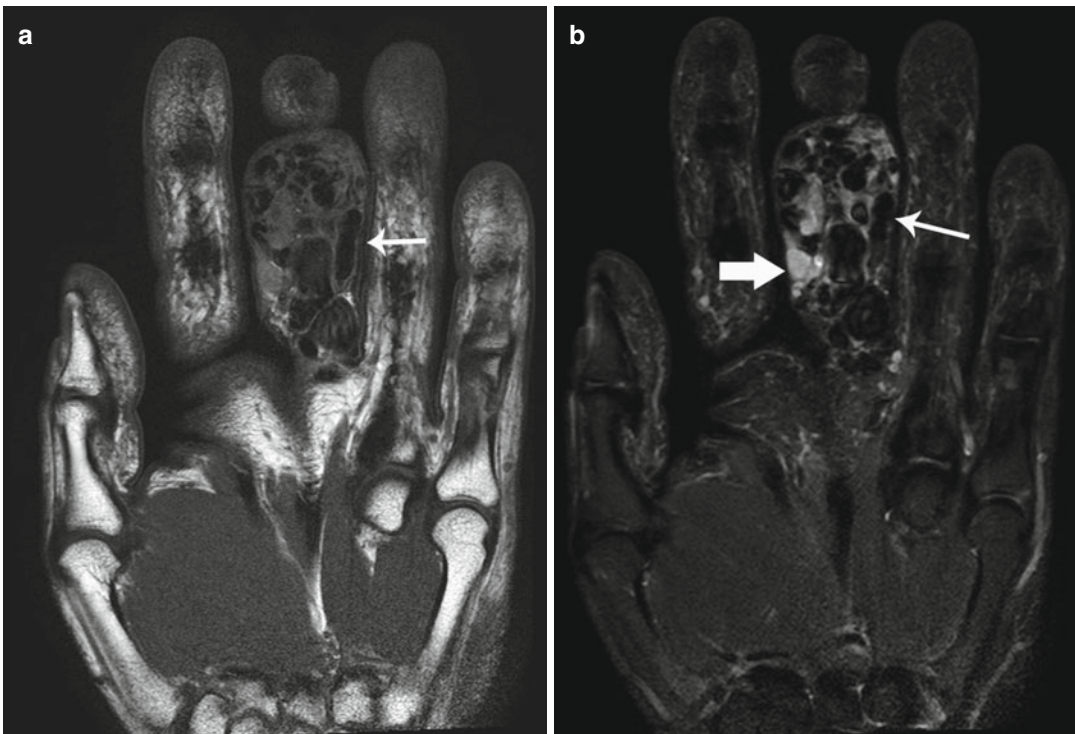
Patient presenting an AVM of the third finger with worsening symptoms of venous congestion. (a) T1-weighted spin-echo acquisition showing the high-flow AVM with multiple vascular channels displaying flow void signals (*arrow*). (b) T2-weighted short tau inversion recovery (STIR) acquisition showing high-flow vessels with flow void on the arterial and venous side (*small arrow*) and several congestive veins with a low-flow paradoxical enhancement (*large arrow*). (c) Time-resolved acquisition (4D track) after gadolinium injection
